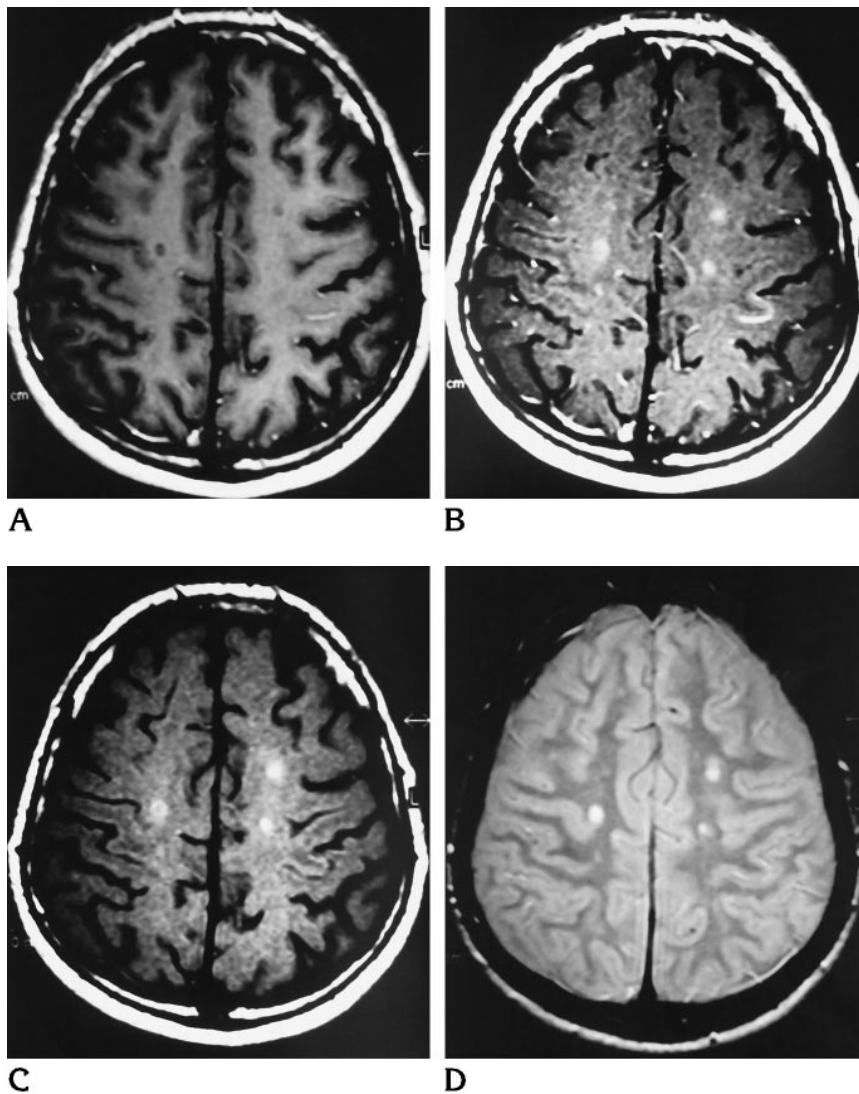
No enhancing plaques are present on the contrast-enhanced conventional T1-weighted spin-echo MR image (A). Three enhancing lesions are seen on the MT T1-weighted image (B); however, they are also seen on the unenhanced MT T1-weighted sequence (C). On the proton density-weighted image, all the lesions appear hyperintense (D).
